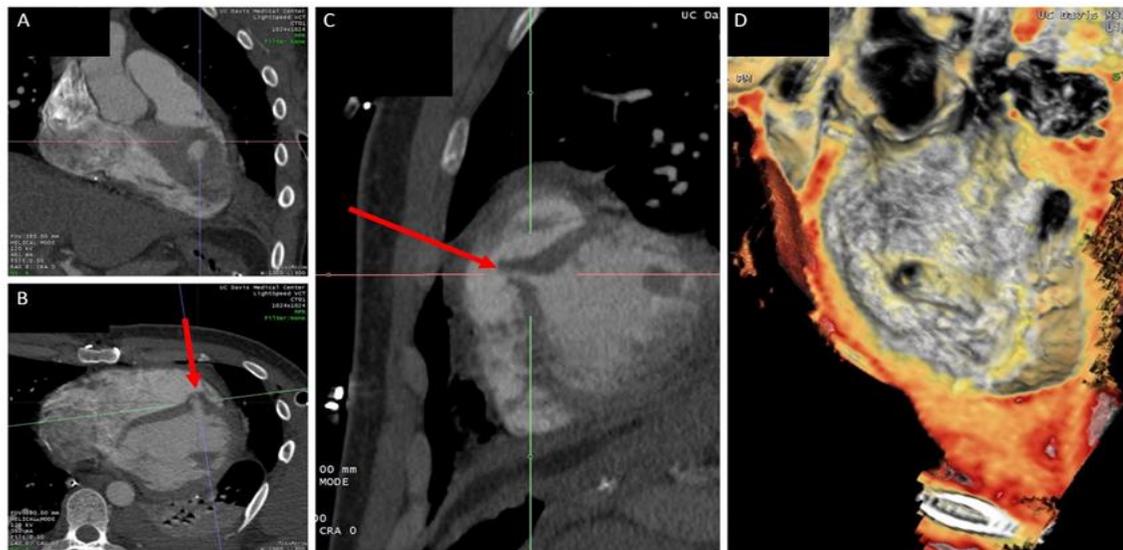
(A) Coronal view from the pre-procedure CT chest showing the defect along the muscular ventricular septum. (B) Axial cross-section view from the same CT study with the red arrow showing the medial to lateral trajectory of the penetrating object. (C) Sagittal view of the defect with red arrow demonstrating the superior to inferior angle of the penetrating object. (D) CT reconstruction with an en face view from the left ventricle of the VSD.
